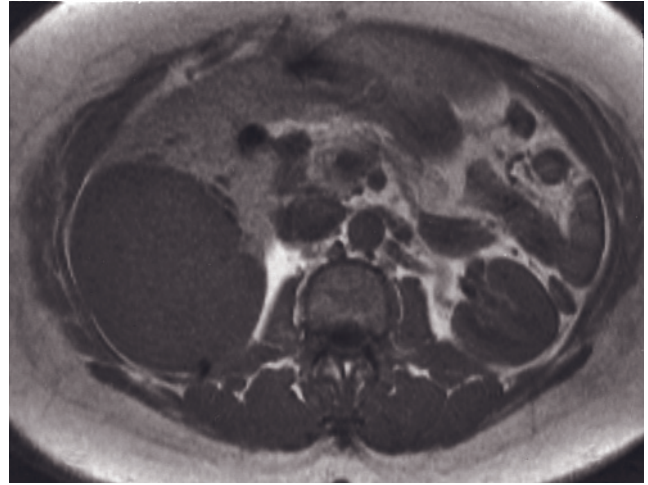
(*Continued*) prominence of periportal area that is intermediate signal intensity on T2-weighted images (*d*) and low signal intensity on T1-weighted images (*e*) and shows minimal enhancement after contrast administration (*f, g*), reflecting infiltration by hypovascular tissue which is well-demarcated. The spleen is massively enlarged in size with multiple hypervascular lesions on immediate postcontrast images (*f*). This patient has coexistent cirrhosis and periportal extramedullary hematopoiesis.
